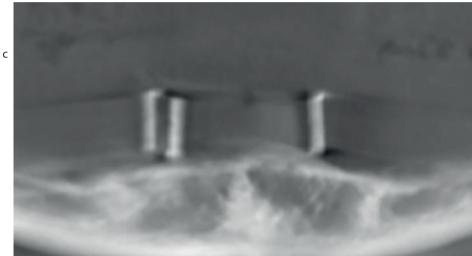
CBCT (a) Sagittal view of radiographic marker at LL3. (b) Sagittal view of radiographic marker at LR3. (c) Coronal view of radiographic marker at LL3 and LR3.
